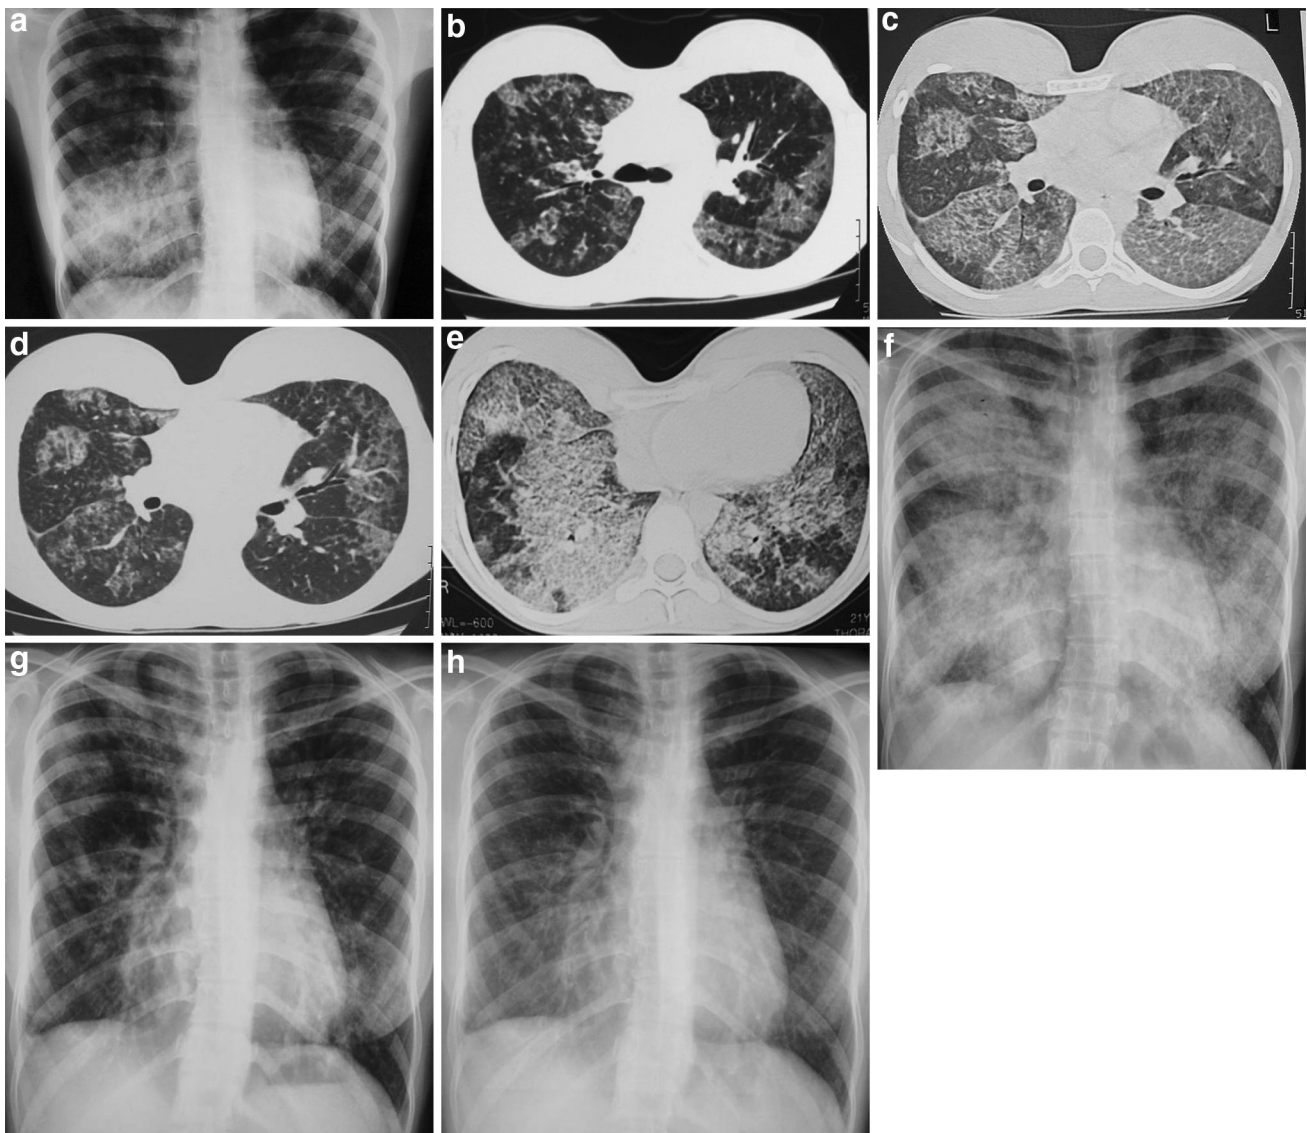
a, b Radiographic and chest computed tomography (CT) images of patient No. 1 (Fig. 5; timepoints 1 and 2) at the time of diagnosis. Note the presence of pectus excavatum deformity and of patchy areas of ground glass attenuation and the sharp demarcation between normal and abnormal parenchyma. A ground glass opacity (GGO) score was calculated, as described by Tazawa et al. [20], and was found to be 3 (25–49 % GGO). c Significant deterioration of the infiltrates with extensive bilateral areas of ground glass attenuation and a superimposed fine linear pattern forming polygonal arcades with a GGO score of 5 (75 % or more GGO) (Fig. 5; timepoint 2). d Significant amelioration of the CT findings related to response to
